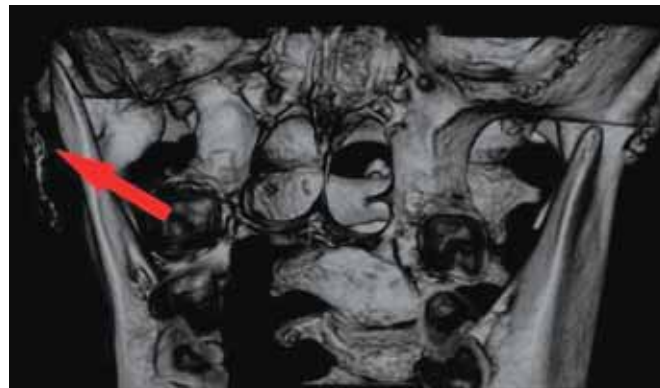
3D CT scan demonstrating proximity of enlarged coronoid process to the inner aspect of the zygomatic arch.
